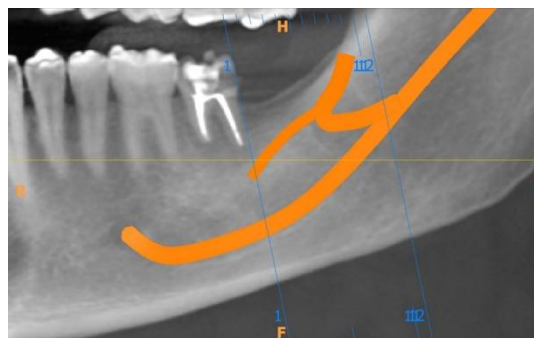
CBCT of case 2 showing Type B2 retromolar canal.
